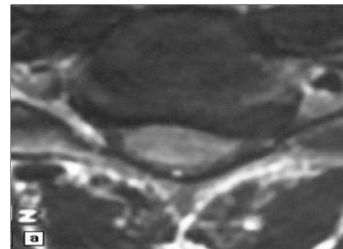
High signal intensity with a length of approximately 2 cm was visible on T2-weighted MRI.
